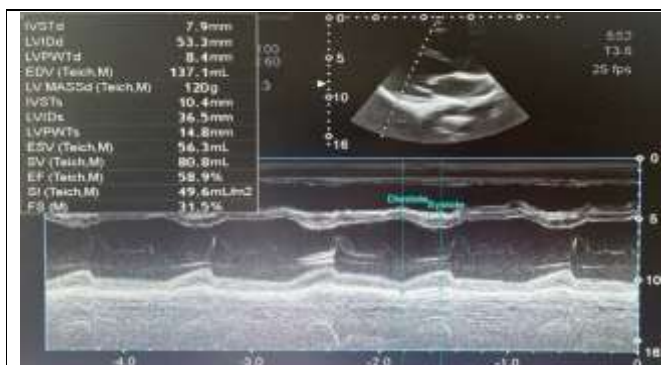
Doppler echocardiography after 9 months: Micro aortic valve regurgitation, 1/4 mitral valve regurgitation, 2/4 tricuspid valve regurgitation, and 1/4 pulmonary valve regurgitation. Pulmonary artery pressure did not increase (26 mmHg). The heart chamber did not dilate. Preserved left ventricular systolic function (EF 58.9%).
